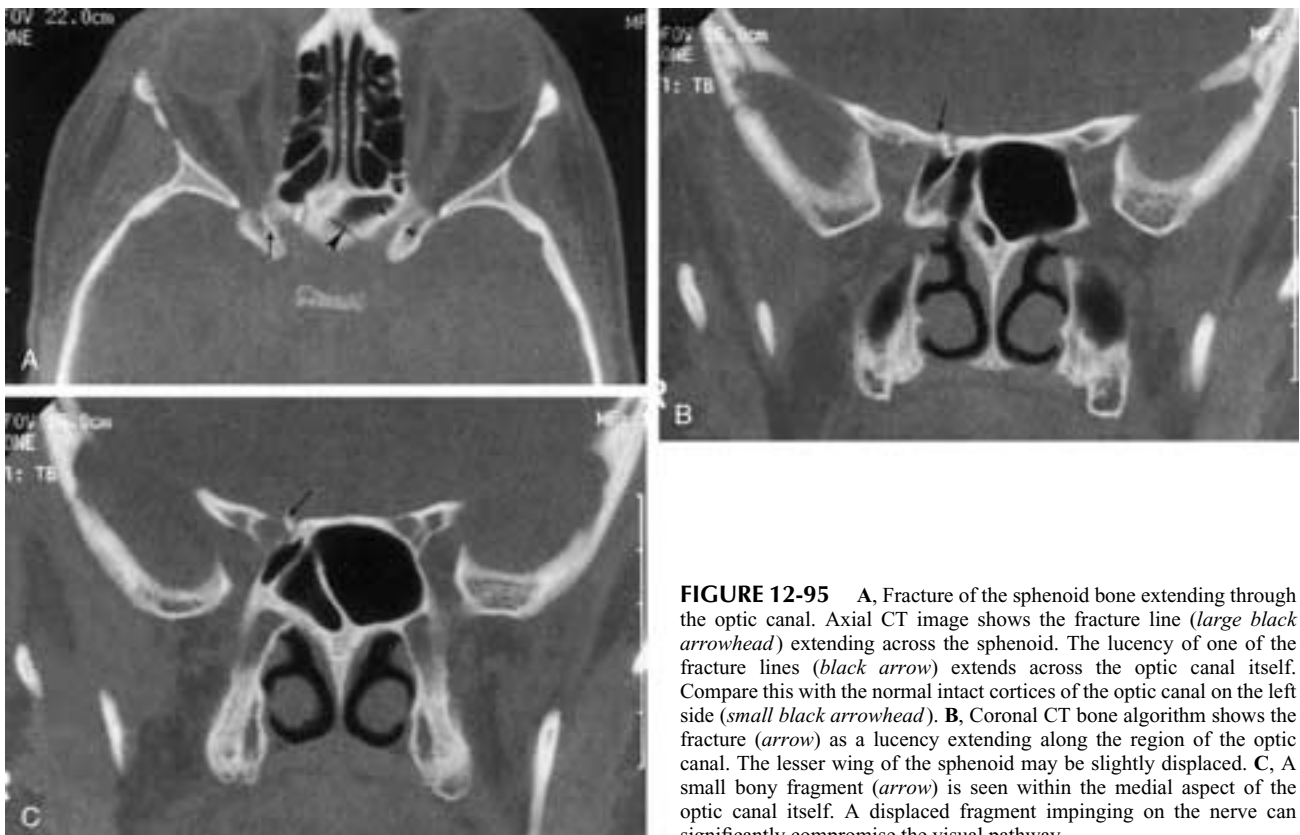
A, Fracture of the sphenoid bone extending through the optic canal. Axial CT image shows the fracture line (*large black arrowhead*) extending across the sphenoid. The lucency of one of the fracture lines (*black arrow*) extends across the optic canal itself. Compare this with the normal intact cortices of the optic canal on the left side (*small black arrowhead*). B, Coronal CT bone algorithm shows the fracture (*arrow*) as a lucency extending along the region of the optic canal. The lesser wing of the sphenoid may be slightly displaced. C, A small bony fragment (*arrow*) is seen within the medial aspect of the optic canal itself. A displaced fragment impinging on the nerve can significantly compromise the visual pathway.
